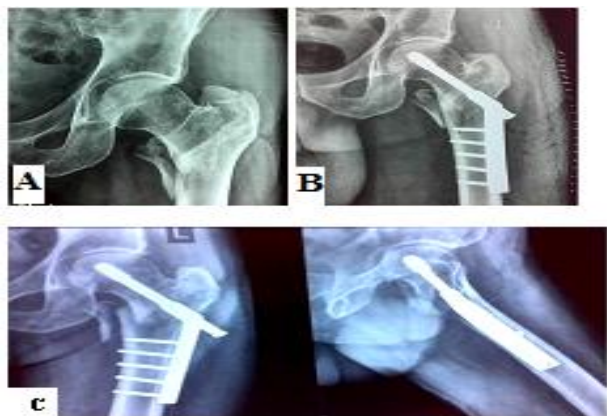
Radiographs of case 1. A= Pre-op X-ray of I/T fracture right trochanter, B= Post-op X-ray with PFN, C= Post-op X-ray with PFN 2 month old with varus fixation.
